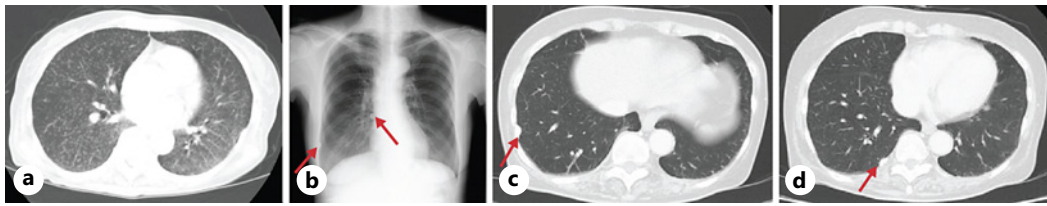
Chest images before and after the development of miliary TB. a Chest CT scan showing diffuse miliary shadows in both lung fields, suggestive of miliary TB. b Pretreatment chest X-ray showing no evidence of pneumonitis or active TB in the lung fields, but calcified lesions of the pleura (arrows) are present. c, d Pretreatment chest CT scan showed pleural calcification (arrows).
